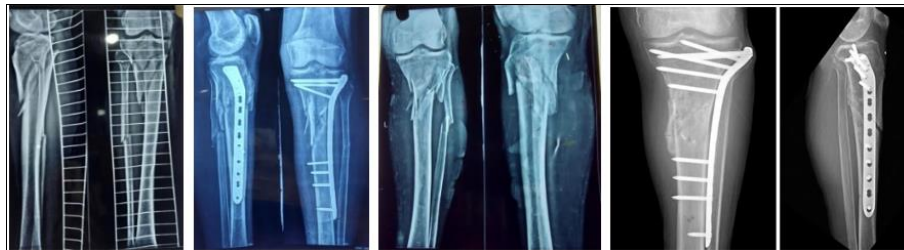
Some pre and post-operative radiographs
